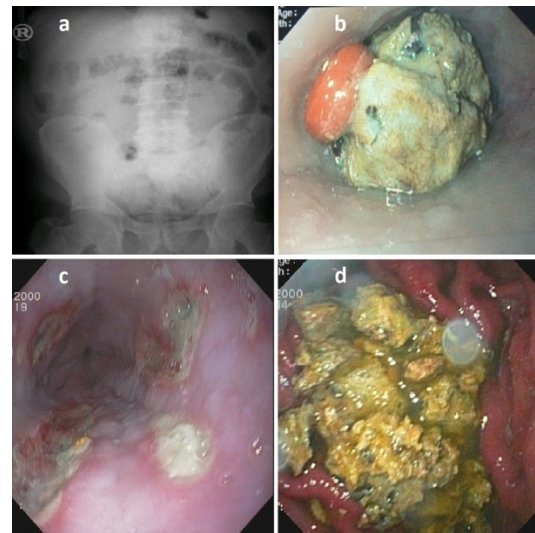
Dilation of the proximal small intestine loops associated with adhesive ileus was evident on standing plain abdominal radiograph (a), phytobezoar in the esophagus containing the drug (b), ulcers caused by esophageal bezoar (c), pieces of bezoar after snare fragmentation (d)
